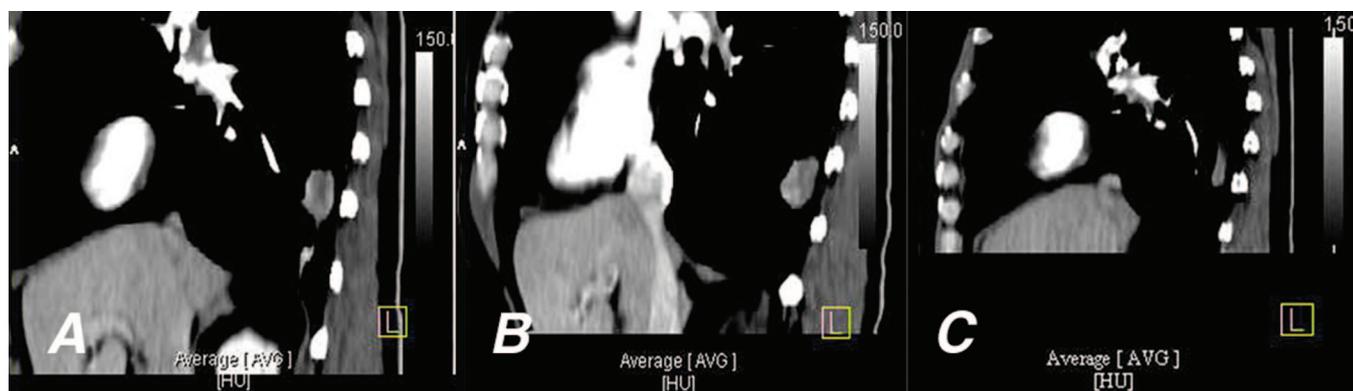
CT sagittal image shows that the maximal diameter of the lesion was 19 mm (A) before starting therapy (January 2010). After 3 months, the lesion showed a stable diameter (B); after 6 months, there was a decrease in morphology (C).
